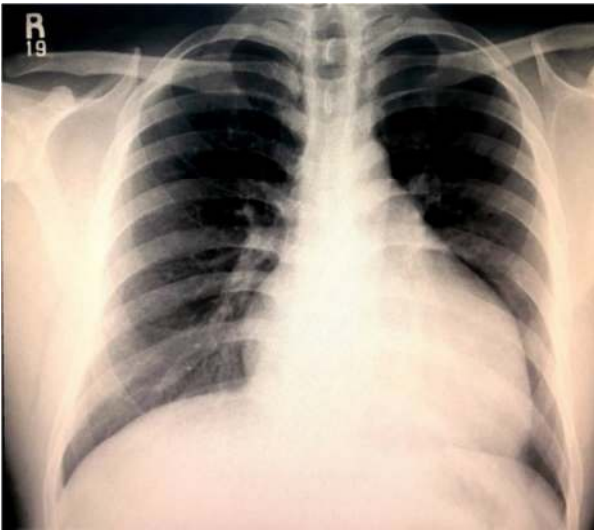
Chest radiography demonstrative cardiomegaly
